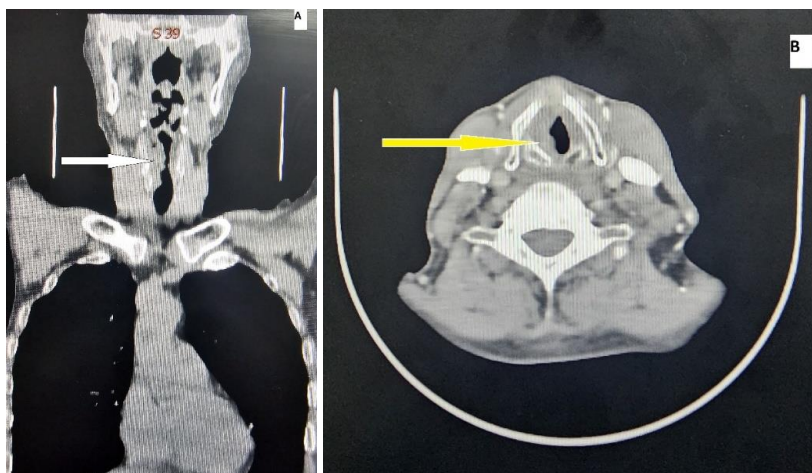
Cervical CT scan on coronal (A) and axial (B) view showed a tumor on the right vocal cord extending into the subglottic region
